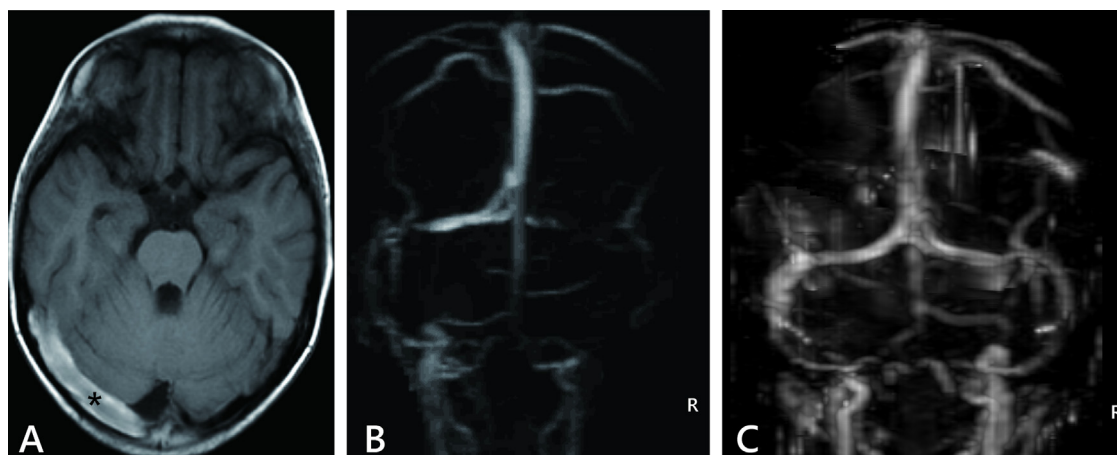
(A) MRI T1-weighted axial image. The high intensity signal in the right lateral sinus indicates thrombus (*). (B) Posterior view on MR venography reveals the absence of flow in the lateral sinus. R indicates the right side of the patient. (C) MR venography performed at 2 months after treatment shows the recovery of flow in the right lateral and sigmoid sinuses.
